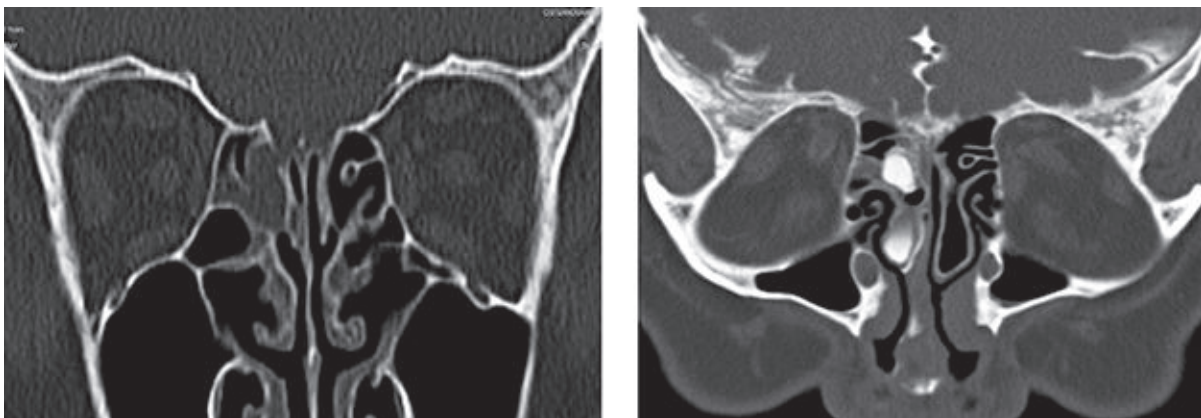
Non-contrast CT with bone window in the coronal plane (A) demonstrates a bony defect at the roof of the right cribriform plate. CT cisternography in the coronal plane (B) shows contrast leakage into the adjacent ethmoidal sinus.
